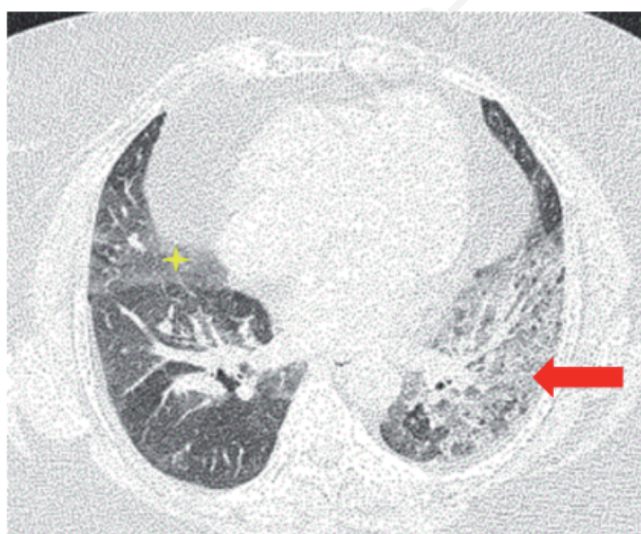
HRCT thorax axial reformatted images at the level of inferior pulmonary vein shows patchy ground glass opacities (yellow asterisk) in bilateral lung fields and a left lower lobe consolidation (red arrow) and a few ill-defined centrilobular nodules.
